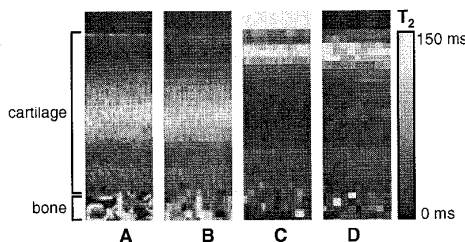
PLM image with original high resolution (A), OR (B) and 1/OR (C) images with vertical resolution similar to MR image, and  $T_2$  map (D) from a representative sample.
